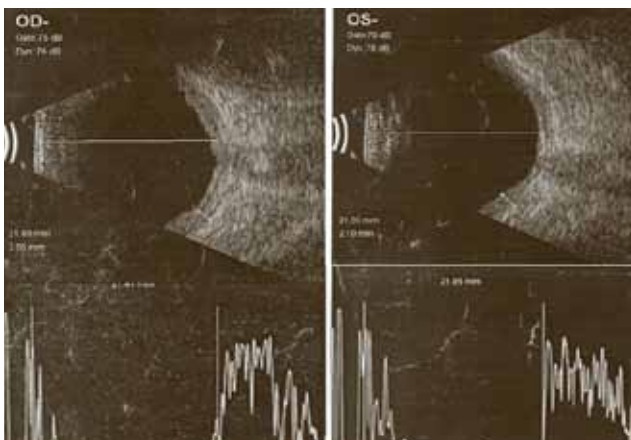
Ultrasonography showing choroidal thickening in both eyes
